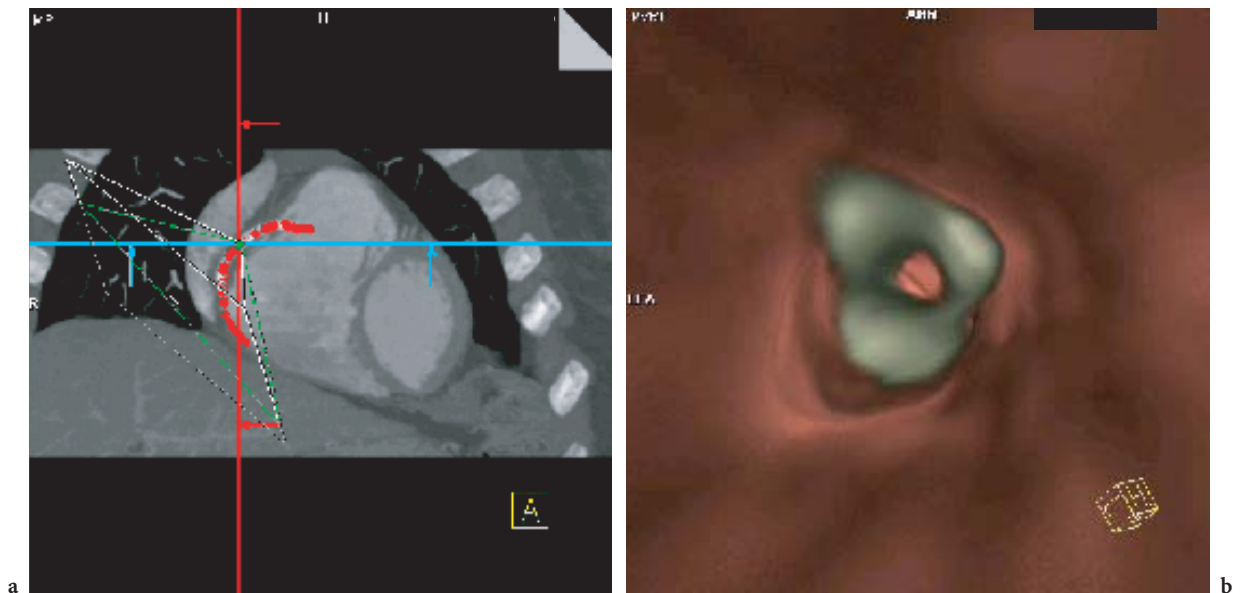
Virtual endoscopic view with VRT visualization of a RCA based on an examination obtained on a 16-slice CT scanner with 16×0.75 -mm collimation. a A path is being planned through the RCA that includes a stent. b The coronary artery lumen and stent struts can be visualized with virtual endoscopy. (Case courtesy of Mt. Sinai School of Medicine, New York, USA)
